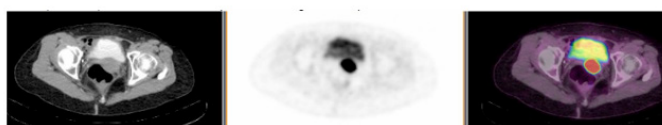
PET CT SCAN. Uterus and ovaries are surgically absent. No discrete enhancing pelvic mass lesion seen in the CT scan. A FDG-avid lesion (SUV 9.1) is seen in the left aspect of the vaginal stump. No evidence of ascites or pneumoperitoneum. No enlarged lymph nodes (abdominal-pelvic-inguinal). No FDG-avid pelvic and abdominal nodes seen.
